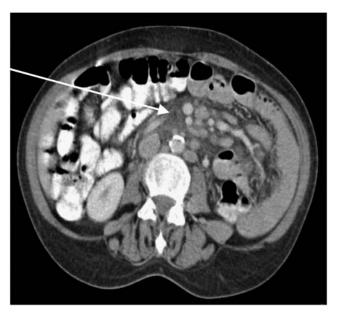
Axial abdominal CT image showing mesenteric fat infiltration (arrow) in patient with EATL.
